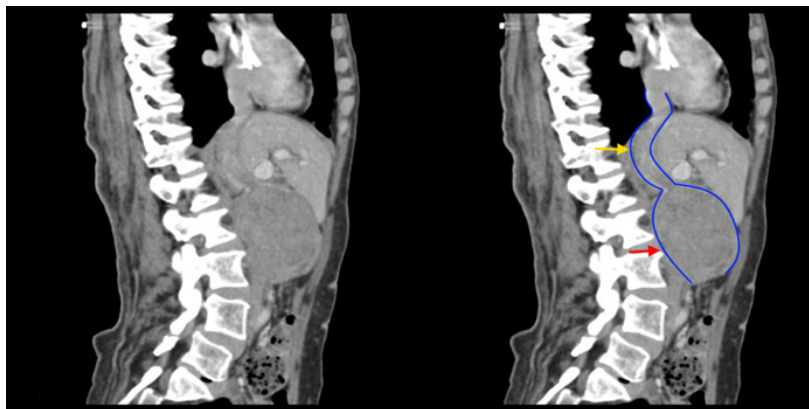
Abdominal enhanced CT in sagittal plan, demonstrating clearly the continuity of the mass (red arrow) with inferior vena cava (yellow arrow).
